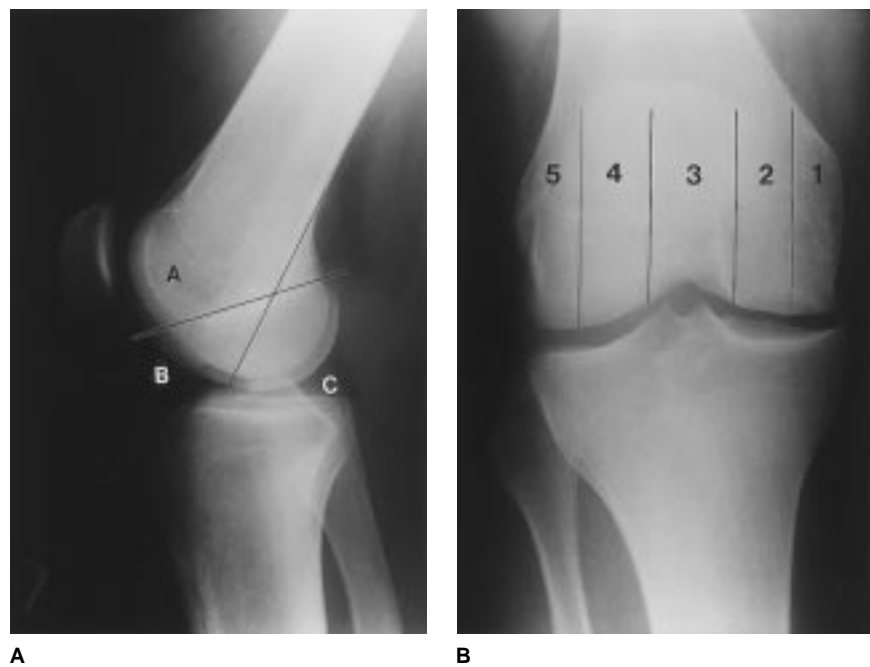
Anatomic locations of JOCD and OCD in the knee. A, Lateral radiograph of a 17-year-old boy with a BC lesion in the medial femoral condyle. Areas B and C are divided by a line projected from the posterior femoral cortex. B, Anteroposterior radiograph of the same patient shows a 1-2 lesion occupying the entire weight-bearing area of the femoral condyle. Numbering of the five anatomic areas begins on the medial side. The condyles are bisected, and area 3 is bounded by the walls of the intercondylar notch. (Reproduced with permission from Cahill BR, Phillips MR, Navarro R: The results of conservative management of juvenile osteochondritis dissecans using joint scintigraphy: A prospective study. *Am J Sports Med* 1989;17:601-606.)
